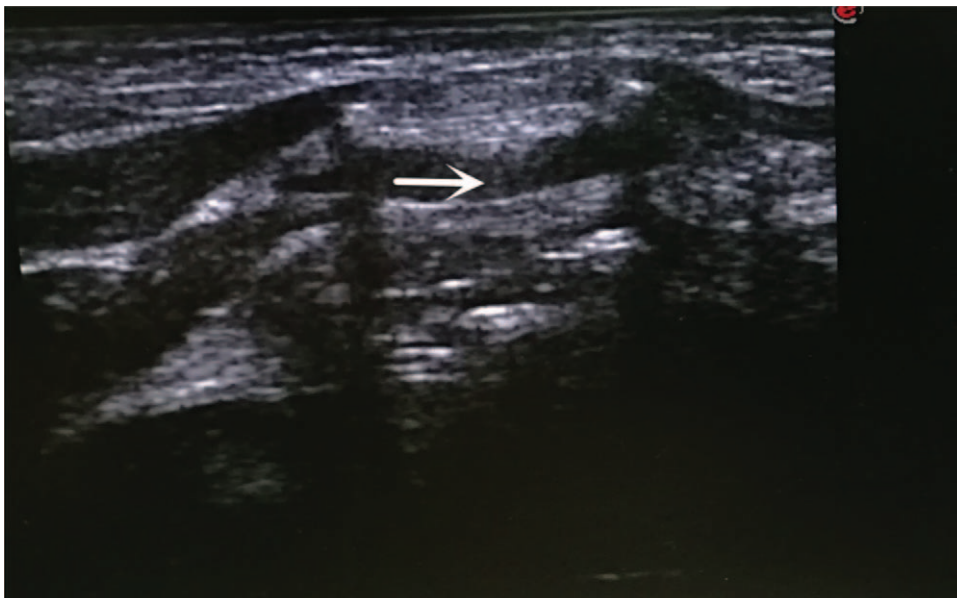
Caudal block under the guide of ultrasound in transverse view. Arrow: needle point in sacral hiatus.
